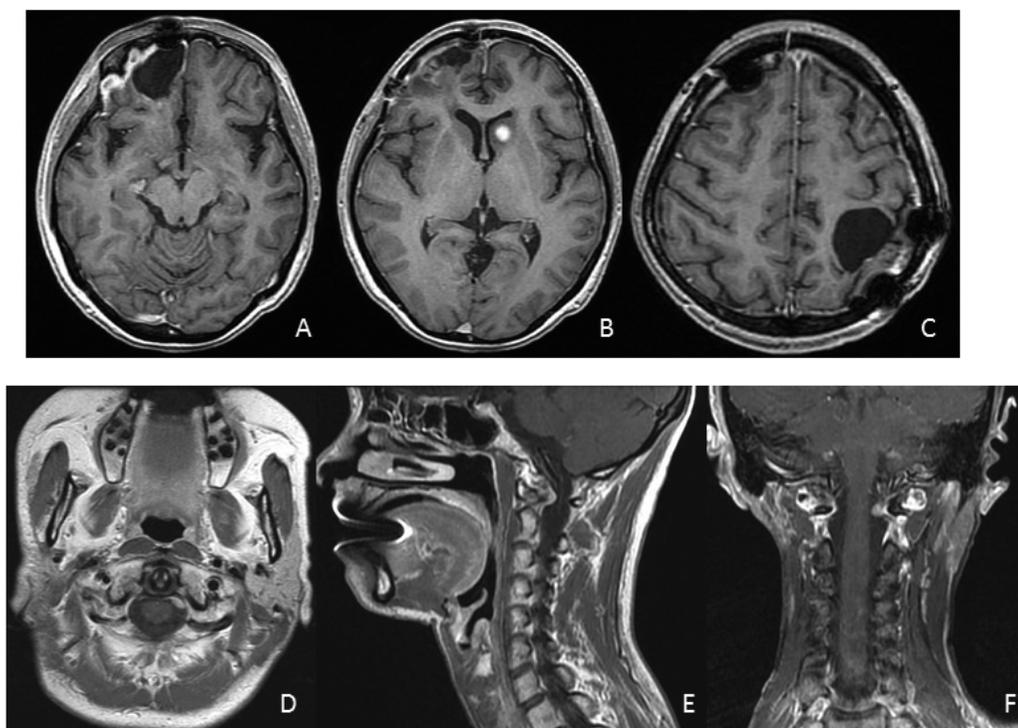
A-C: MR T1-weighted images with gadolinium show mild enlargement of the left head of the caudate nucleus lesion 3 months after the operation (A), but not presenting recurrence as mass lesions at left frontal and right parietal lesions (B, C).
